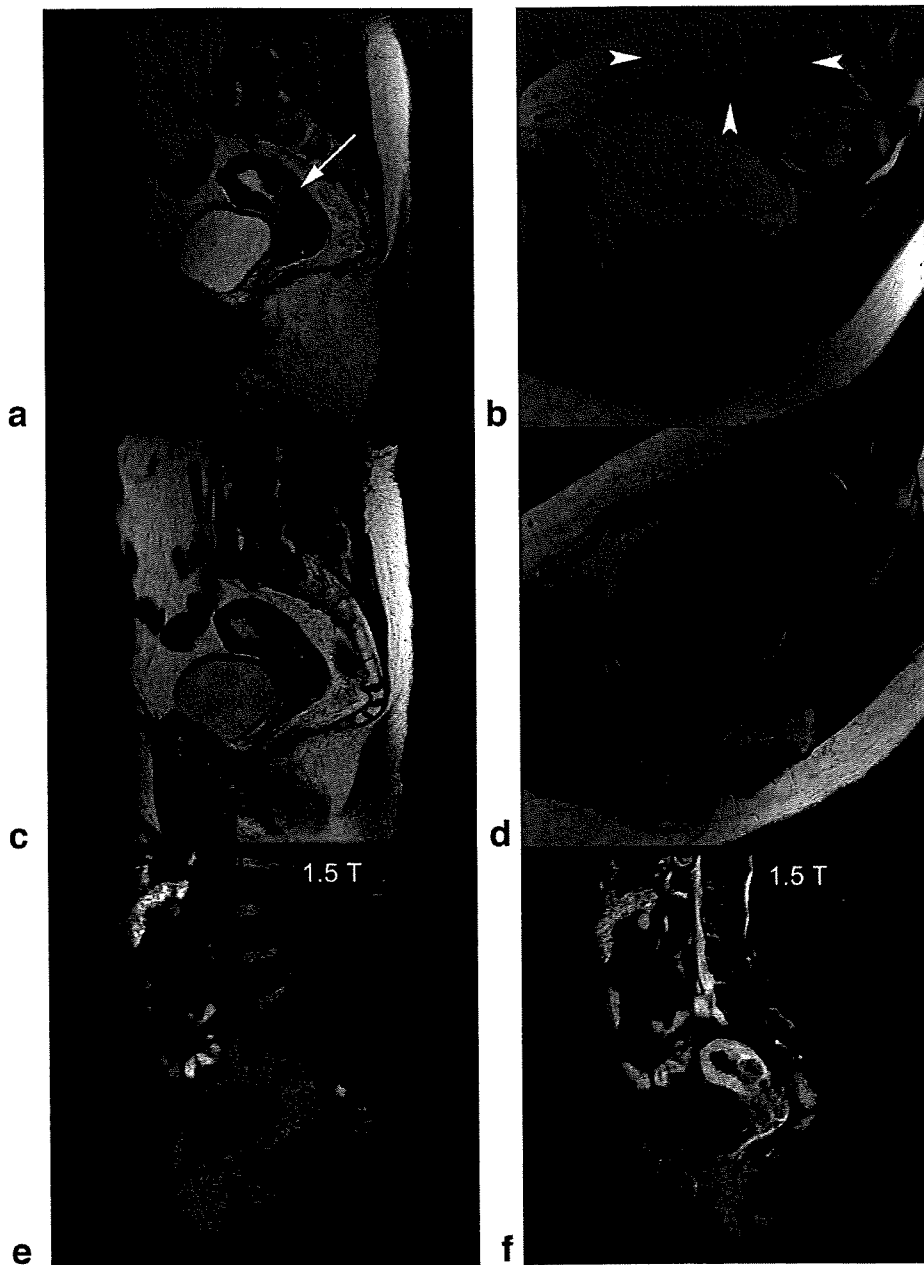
MR images of a 69-year-old woman with endometrial carcinoma (endometrioid adenocarcinoma, grade 1). a,b: T2-weighted fast spin-echo images in (a) the parasagittal plane of the uterus and (b) paraxial plane obtained at 3.0 T (6000/90, 18-echo train length) clearly show the tumor with deep myometrial invasion (arrow), which was confirmed by surgicopathologic findings. c,d: T2-weighted fast spin-echo images in (c) the parasagittal plane of the uterus and (d) paraxial plane obtained at 1.5 T (4000/90, 12-echo train length) show the same findings. Signal intensity of the tumor at 3.0 T is higher than that at 1.5 T, while image homogeneity is slightly better with 1.5 T imaging than 3.0 T imaging. Signal loss artifact due to dielectric effects is seen on the image at 3.0 T (arrowheads). e,f: T1-weighted 3D gradient echo images (4.6/2.3, 12°) at 1.5 T in the parasagittal plane obtained (e) before and (f) 70 seconds after contrast injection show slightly better image homogeneity compared to those at 3.0 T (see Fig. 5).
